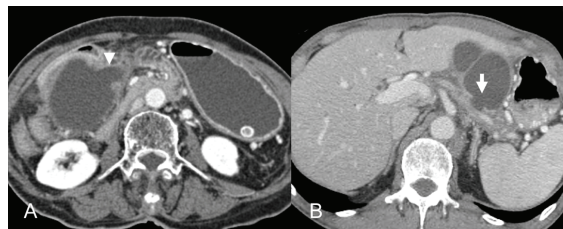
A 78 year-old female with abdominal pain and palpable abdominal mass: Axial post contrast CT scan (A) show unilocular cystic lesion with pseudopod sign (arrow head) at head of pancreas. Axial post contrast CT scan of another patient (B) demonstrated the same appearance of pseudopod sign in pseudocyst at body of pancreas
